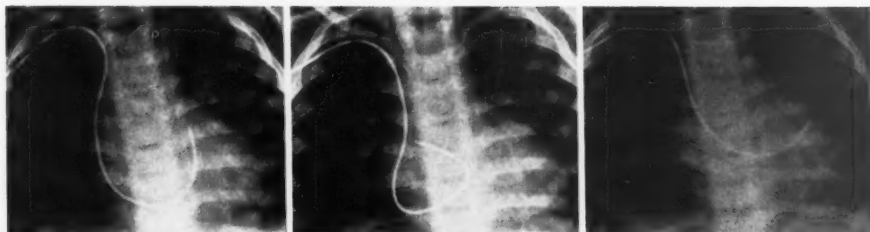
Roentgenograms of the thorax showing the position of catheters in the outflow portion of right ventricle (*left*), the root of the aorta (*middle*) (proved by indicator-dilution curves) and the left ventricle (*right*). The aortic valve was not displaced cephalad and to the right as usually seen in cases of transposition. Unfortunately a lateral roentgenogram was not obtained. In each instance systolic and diastolic pressures and oxygen saturation values are given.
